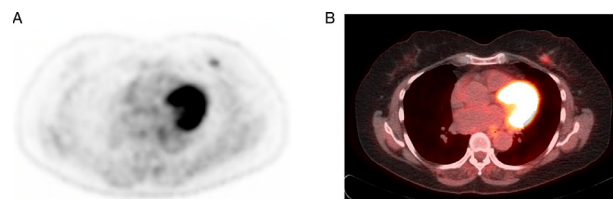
64-year old female who underwent FDG-PET/CT for evaluation of a solitary pulmonary nodule. A small lesion was found in the left breast (Fig 2A, 2B) with mild increased metabolic activity (SUVmax of 2.6). Subsequent biopsy showed a benign finding (sclerosing adenosis with ductal hyperplasia and apocrine metaplasia with associated microcalcifications).
